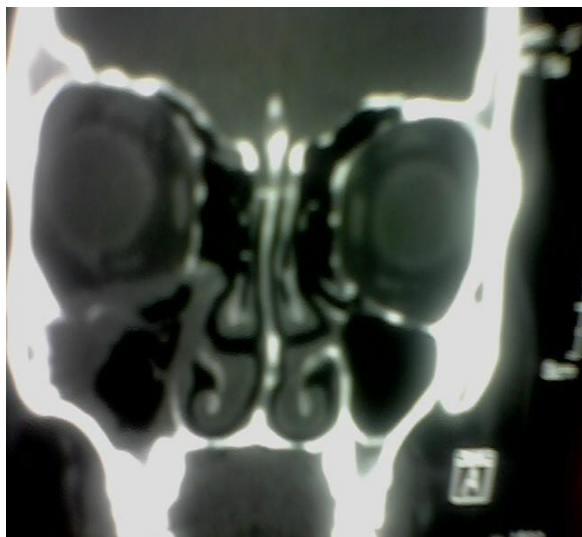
Coronal cut of contrast enhanced computed tomography (CECT) showing right maxillary sinusitis
